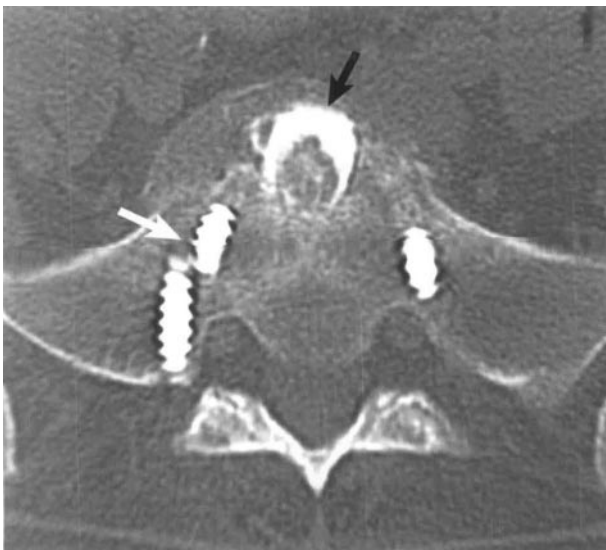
Broken pedicle screw. CT scan shows the fractured right S1 pedicle screw (white arrow). A Bone Dowel (black arrow) is present in the L5-S1 disk space.
